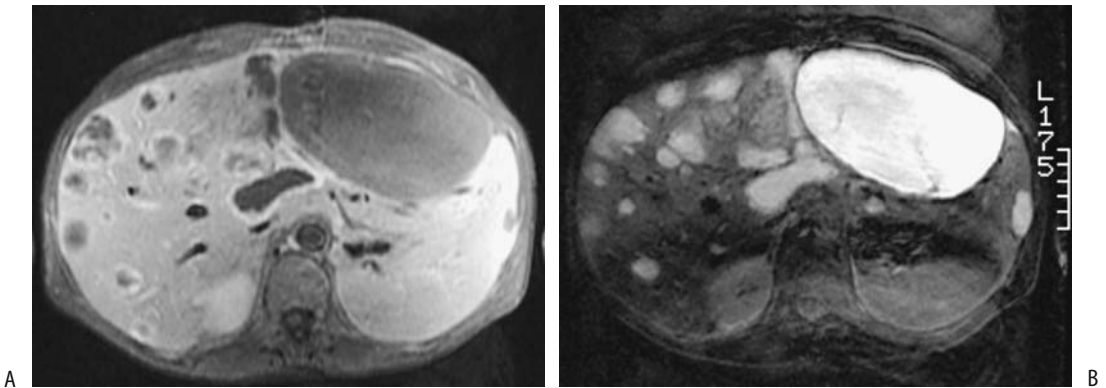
Metastatic leiomyosarcoma. A T1-weighted MRI (A) reveals multiple hypointense and a T2-weighted image (B) reveals hyperintense tumors. The patient had a primary sarcoma resected about 10 years previously. (Courtesy of Patrick Fultz, M.D., University of Rochester.)
